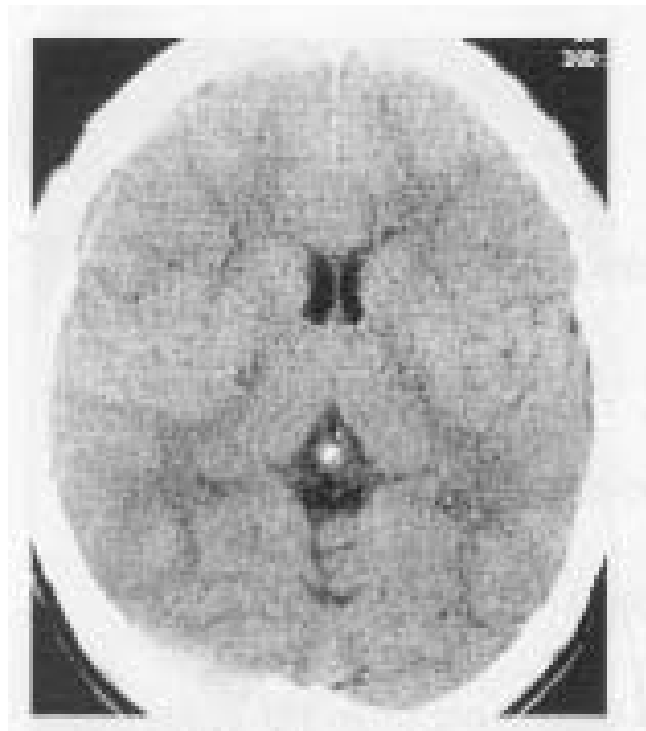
Noncontrast axial head CT scan shows a dense right transverse sinus.
